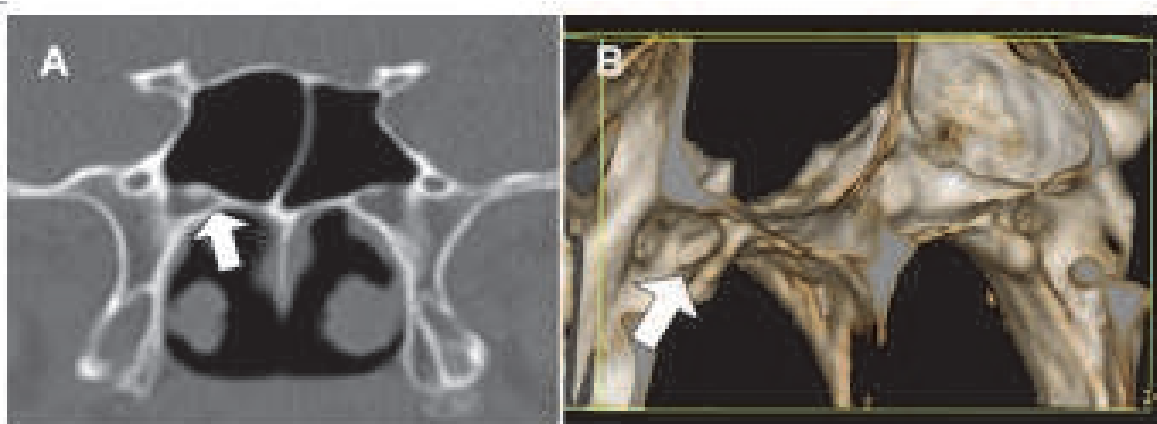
The presence of palatovaginal canal (arrow) can be demonstrated on A: coronal CT slice and more clearly on B: 3D reconstruction image.
